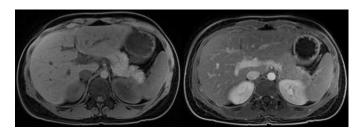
Magnetic resonance imaging of the abdomen showing normal pancreatic volume and signal density, normal pancreatic ducts, and the absence of gallstones, defining resolution of pancreatitis.
